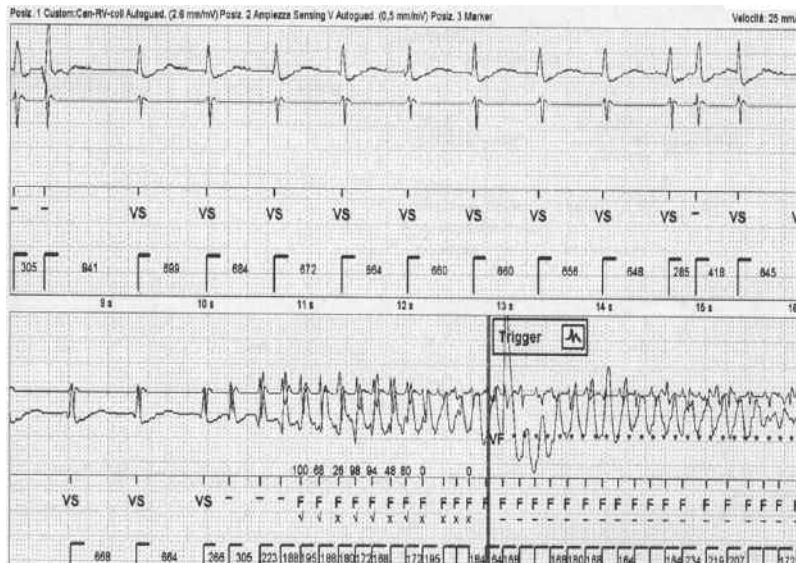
In the Holter echocardiogram, the onset of ventricular tachycardia is visible with inefficient overdrive.
